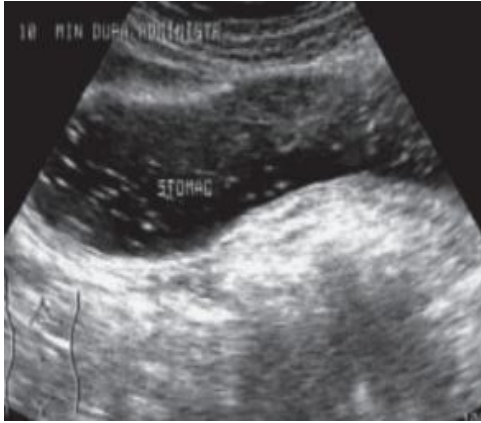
Sonogram of the stomach filled with water Fig 5: Sonogram of the small intestine filled with water
